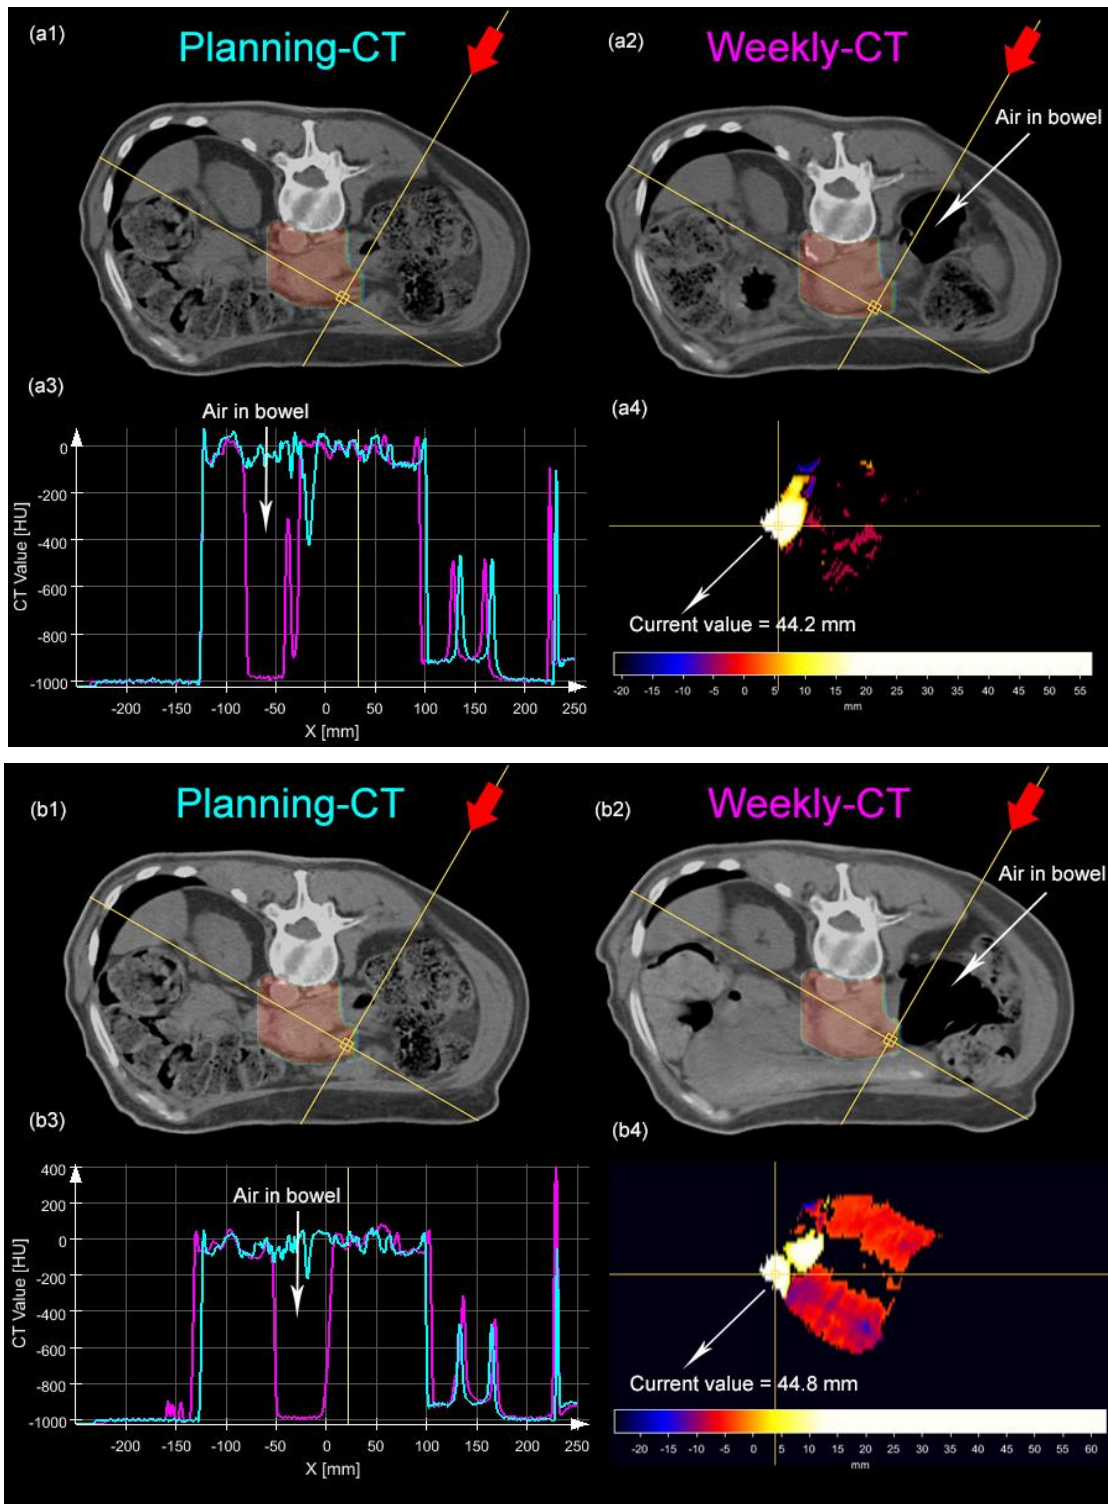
Point analysis for Patient J (a) For Weekly-CT1, field 2, (b) For weekly-CT3, field 2. The bowel changes effect from planning-CT and weekly-CT can be observed in CT value (HU) and also in accWEPL difference map. In (a4, b4) the current value is the accWEPL value for the specific beam indicated by red arrow in (a1, a2, b1, b2). The important thing is the area of the difference map in (a4) filled with variations, most of the area is black which represents points within $\pm 3\text{mm}$. (Note: Apparently scan images are deformed because of the couch angle used and this is how software will look through that beam; the software doesn't apply this deformation while calculating accWEPL)
